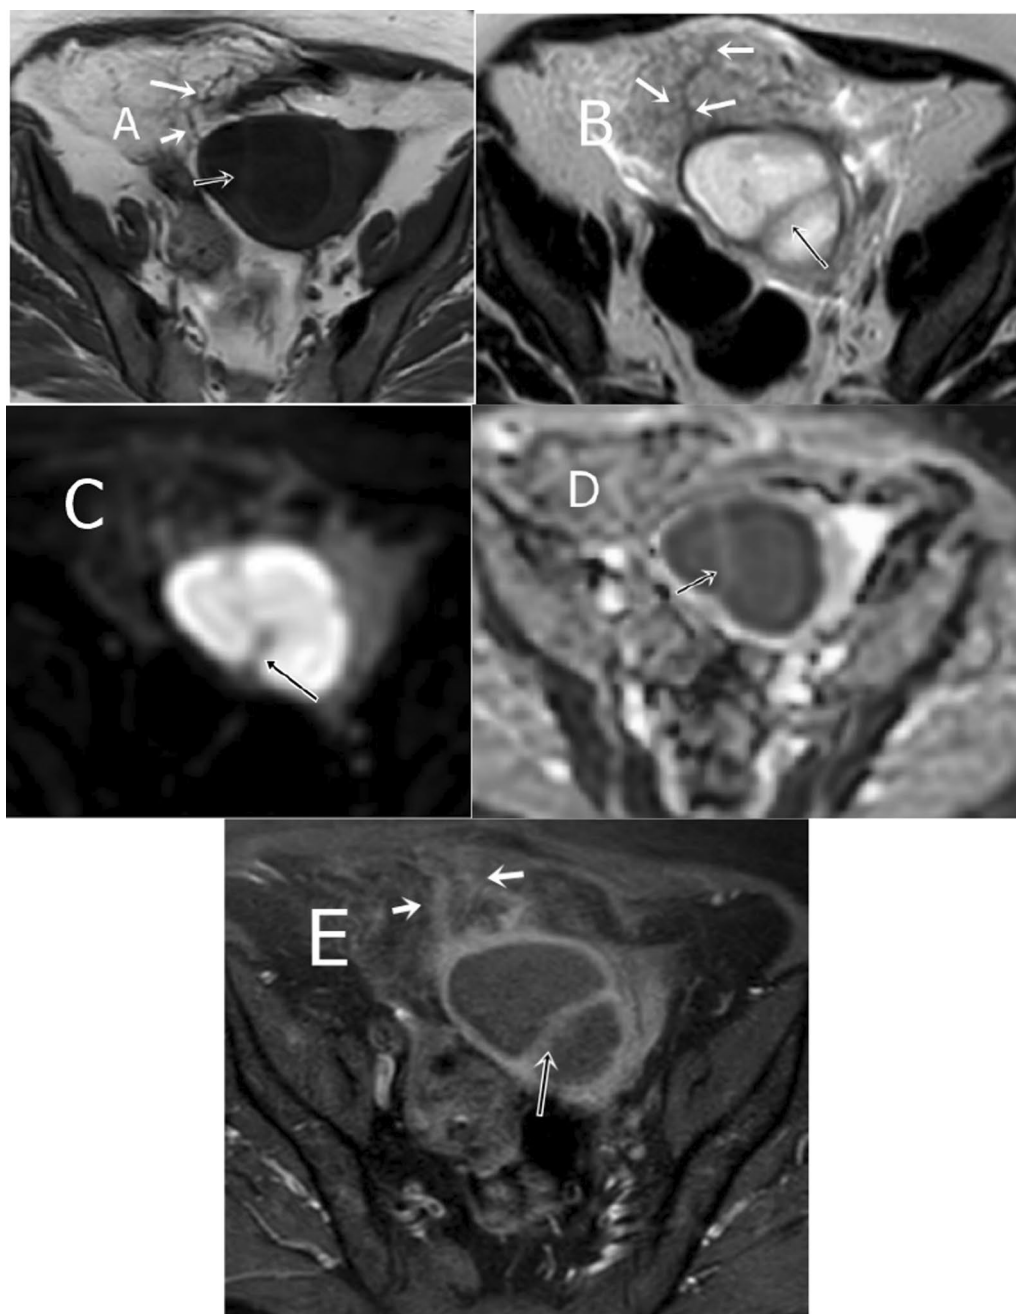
O-RADS MRI score 3 in 53-year-old female with left pelvic pain A Axial T1WI, B axial T2WI, C, D DWI and ADC images: left adnexal bi-locular cystic lesion with thick wall and septae (black arrows) that displays low T1 and high T2 SI with thickening and stranding of surrounding fat planes (likely edema, white arrows), E Axial T1 post-contrast image shows thick marginal and septal enhancement but no associated solid component. This was diagnosed as left tubo-ovarian abscess
